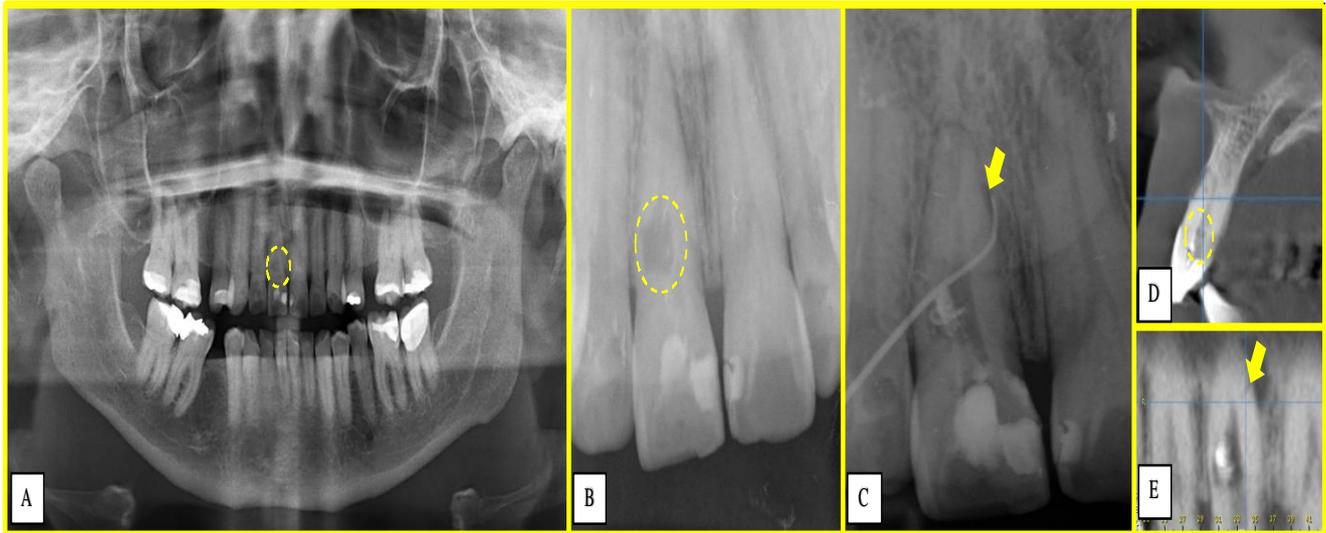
(A) Orthopantomography with radiolucent area in the cervical third of the dental organ 1.1 (dotted circle), (B) Preoperative coronaoapical radiograph, resorption area (dotted circle), (C) Fistulography shows the fistulous path of the lateral canal (yellow arrow) in the middle third of the root, (D) Dentin resorption of the root canal in the cervical third (dotted circle) without communication with the periodontium, (E) Computed tomography, apical lesion in the middle third through the lateral canal (yellow arrow).
